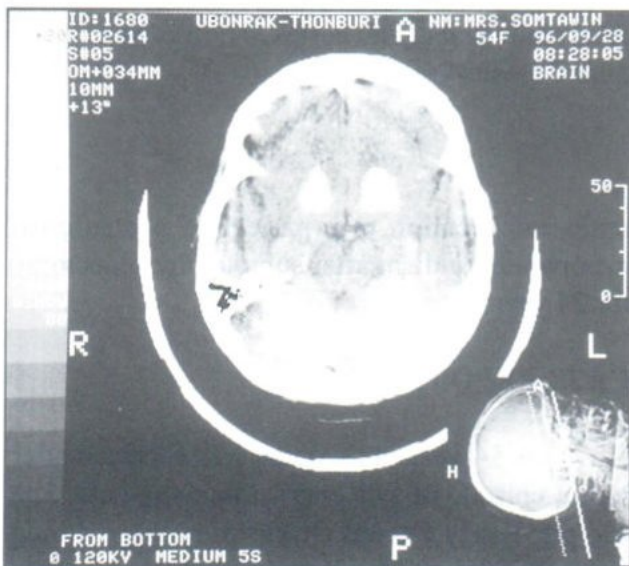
Noncontrast computed tomography of brain. A slice through the posterior fossa demonstrates calcifications of dentate nuclei and cerebellar white matter.
